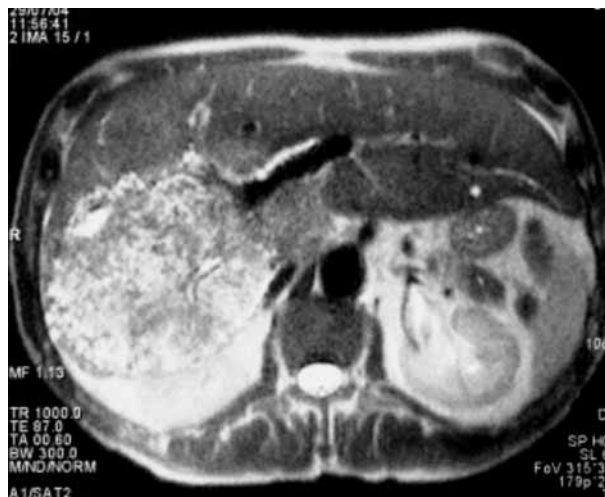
Magnetic resonance imaging of the liver (case 3), showing a large, polycystic mass of the right liver.
